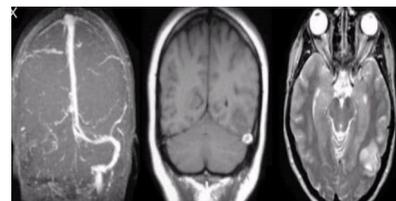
MRV shows the absence of left transverse and sigmoid sinuses(left), T1-weighted coronal MRI shows clot within the left transverse sinus(middle), T2 weighted axial MRI shows hyperintense signal in left posterior temporal lobe (right)
